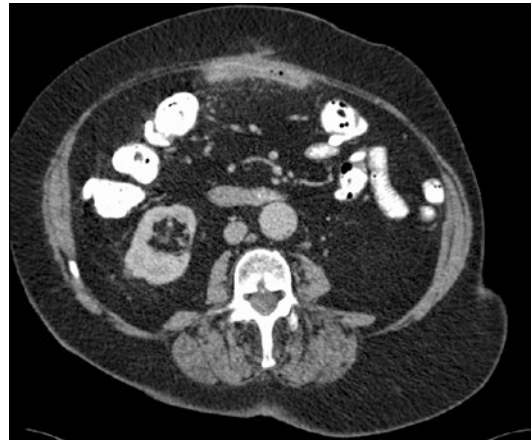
Mesh is visible as a thin white line on this CT axial view. Note the fluid collections anterior and mostly posterior to the mesh. There are gas bubbles in the fluid, consistent with an infected fluid collection associated with the mesh, and thus also a mesh infection
